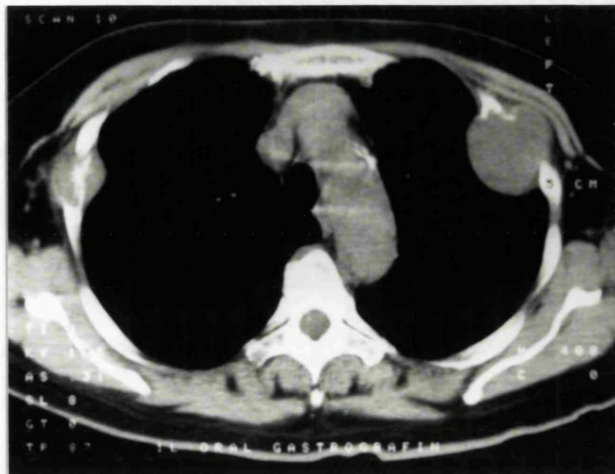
CT scan showing bilateral expanding rib lesions with associated soft tissue masses.
